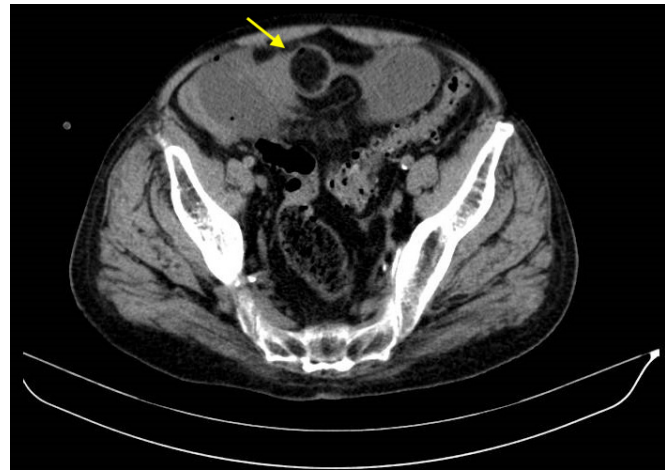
CT-scan findings.
